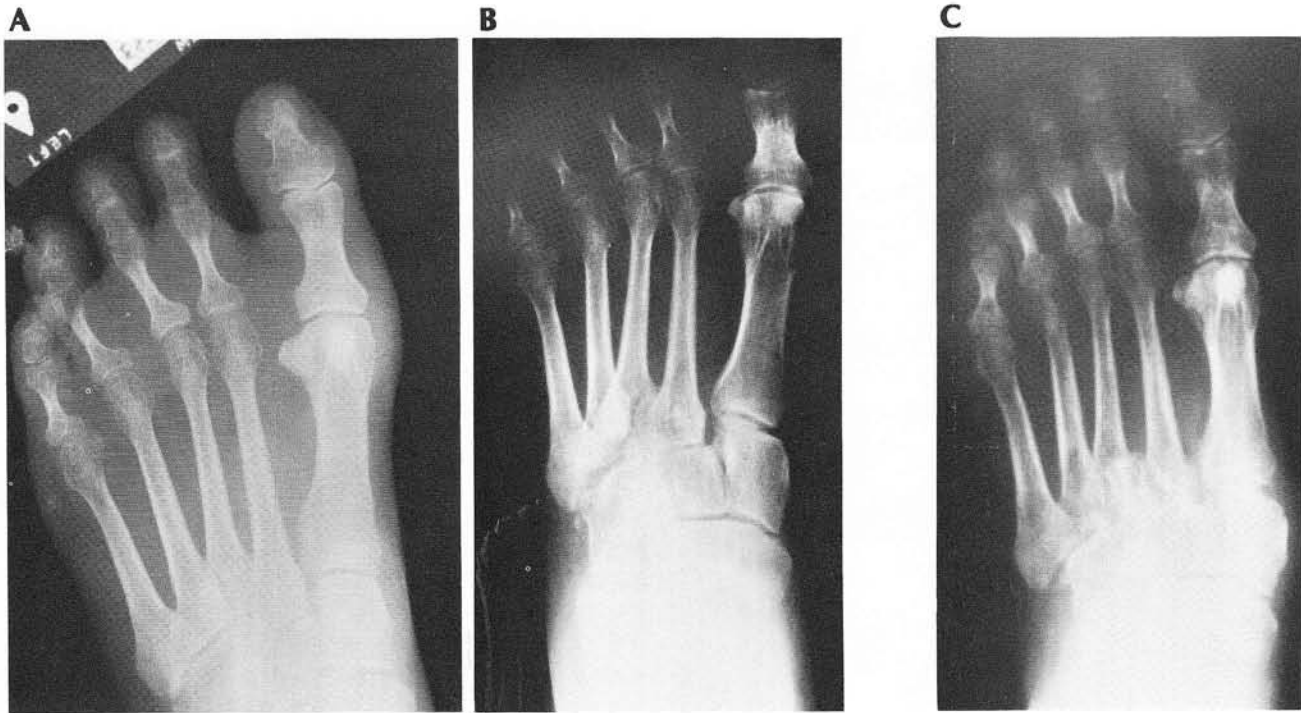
A. Radiographs of 52 year old white female before injury to tarsometatarsal joint. B. Following dislocation of LisFranc's joint. C. One
